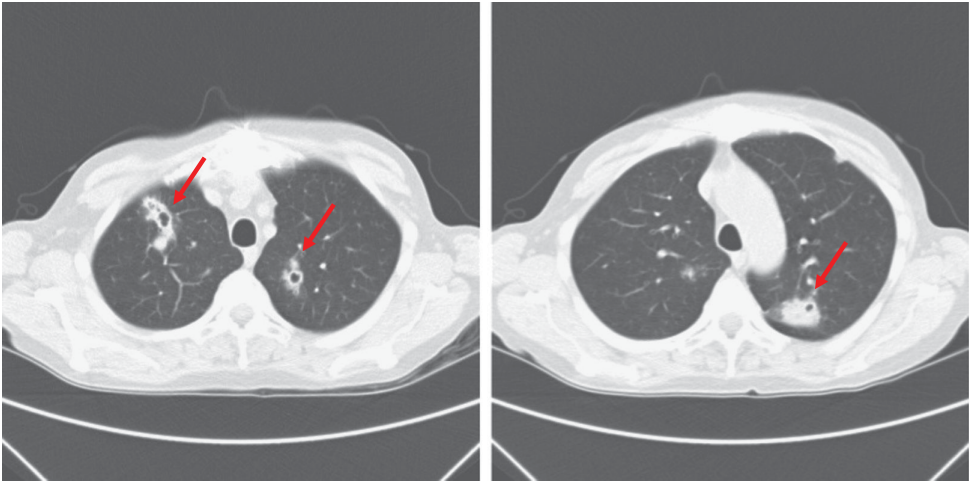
CT chest demonstrating bilateral multifocal cavitary pulmonary nodules.
